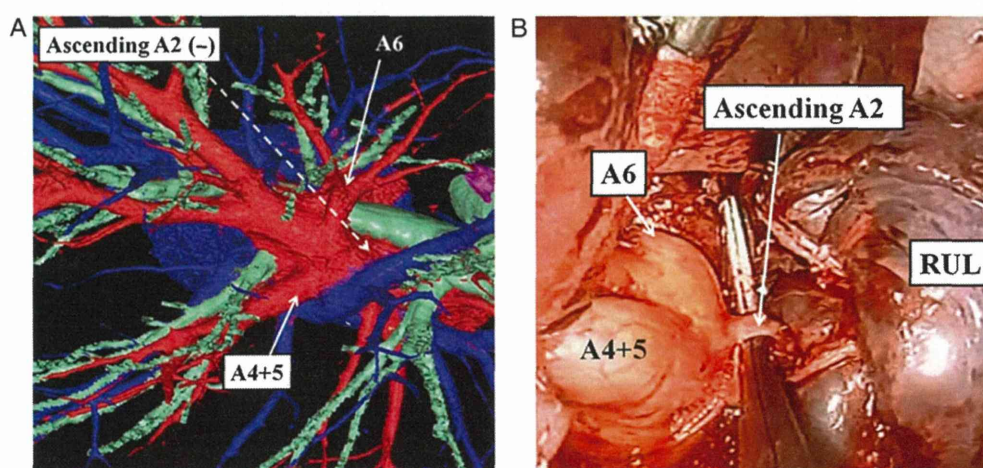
(A) A 3-dimensional computed tomographic image of the right pulmonary vessels. In this patient, a right upper lobectomy was performed. An ascending artery was not detected. (B) The intraoperative findings in this patient demonstrated the 2-mm ascending artery branches from the pulmonary artery.
